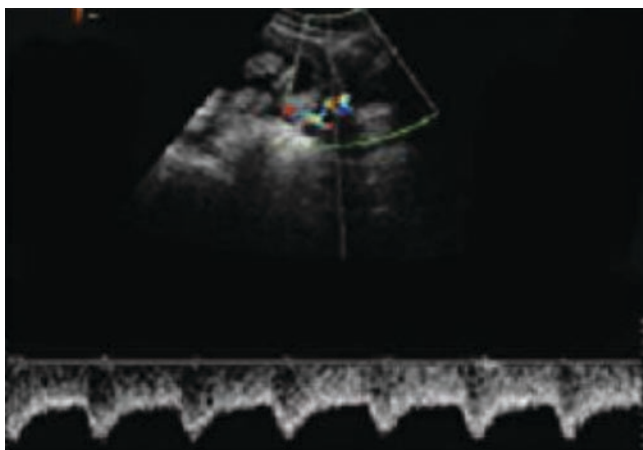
Color Doppler spectrum of the uterine artery during pregnancy
